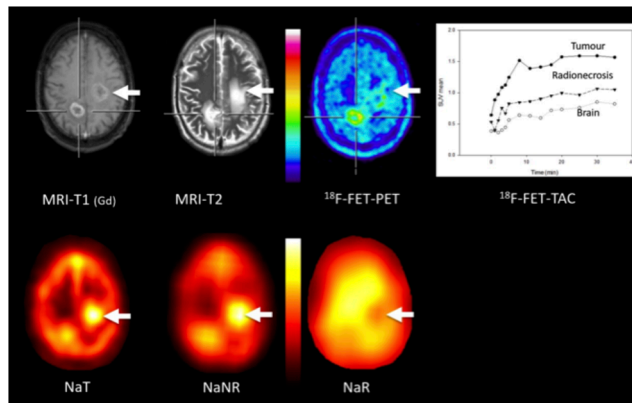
MRI and PET of a 50-year-old male patient with a recurrent IDH wildtype glioblastoma WHO grade IV in the right parietal lobe and a radiation injury on the contralateral side (white arrows), both confirmed by follow-up. Both lesions exhibit contrast enhancement in the T₁-weighted MRI and diffuse abnormalities in the T₂-weighed MRI. [^{18}F]FET-PET is positive in the recurrent tumor and negative in the necrosis. Sodium imaging shows more prominent abnormalities in the radionecrosis.
